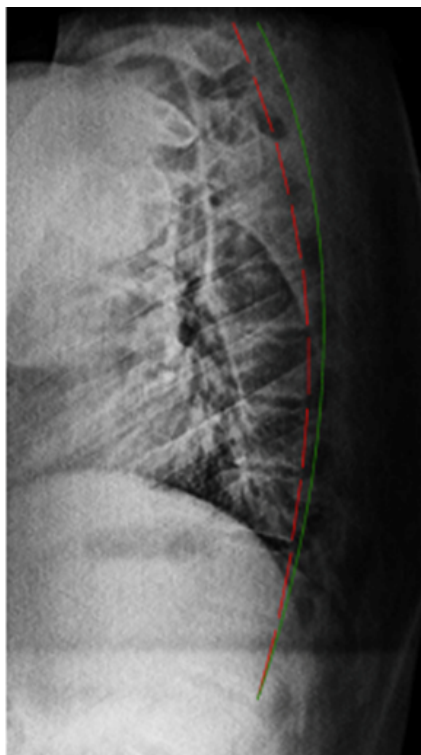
LT X-ray after 36 Visits (7 Weeks). The green line represents the Normal Spinal Position and expected path of the posterior longitudinal ligament; The red line represents the patient's position known as George's Line. This is the path of the posterior longitudinal ligament.
